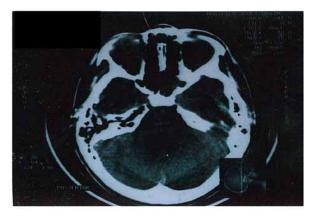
CT scan - one month after surgery.
